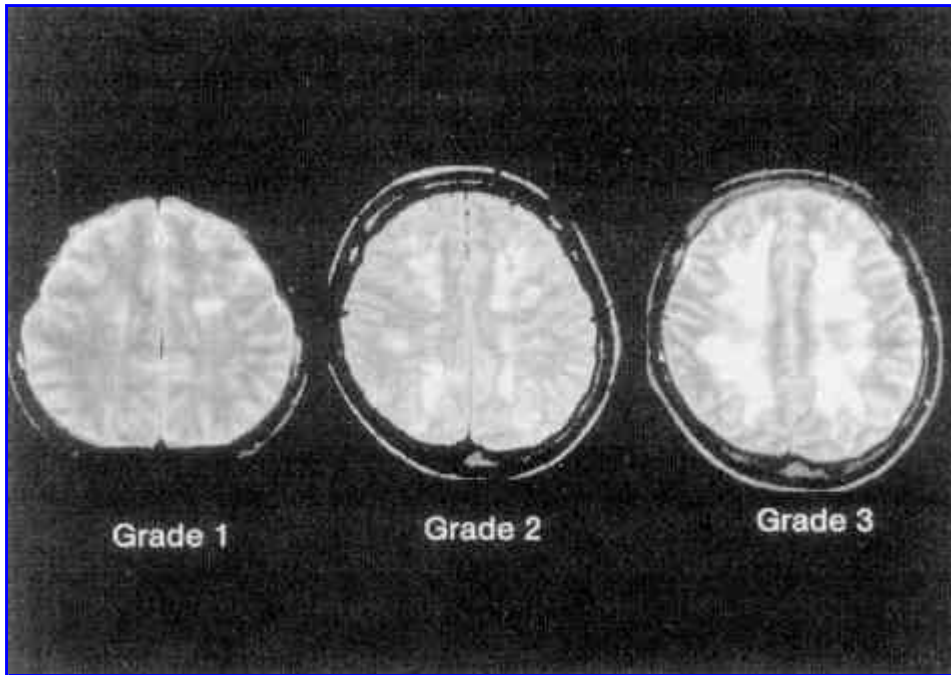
MRI grade for cerebral fat embolism. MRI findings were graded into four categories according to the severity of the brain lesions observed on MRI-T2WI images. Grade 0, no abnormalities; grade 1, several small spotty high-intensity lesions seen in the deep white matter or deep brain structures; grade 2, either many small high-intensity lesions or macular lesions, which represented confluence of the spotty lesions in the deep white matter or deep brain structures; grade 3, large macular high-intensity lesions in the deep white matter.
